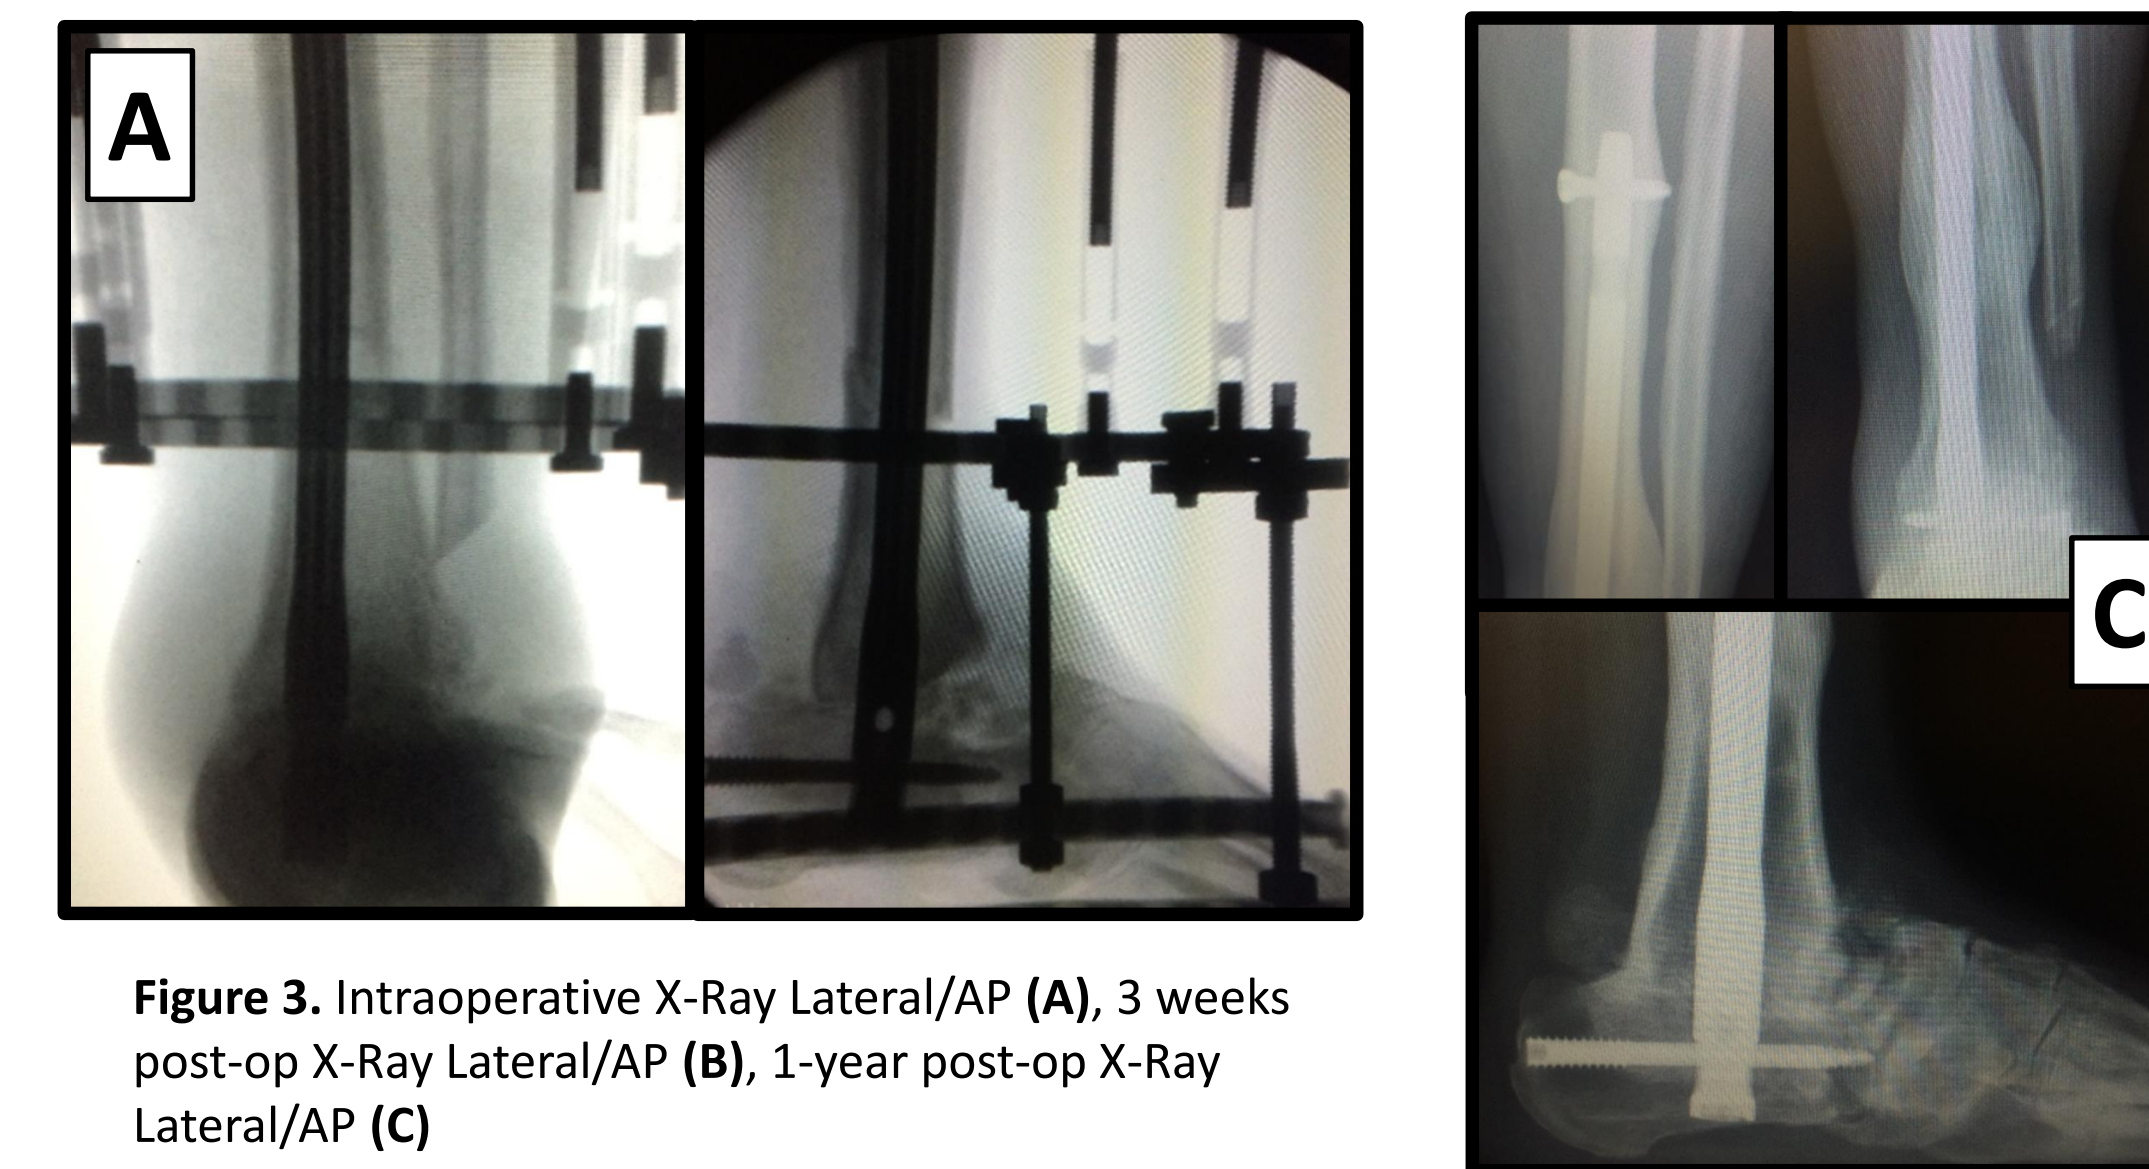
Intraoperative X-Ray Lateral/AP (A), 3 weeks post-op X-Ray Lateral/AP (B), 1-year post-op X-Ray Lateral/AP (C)
